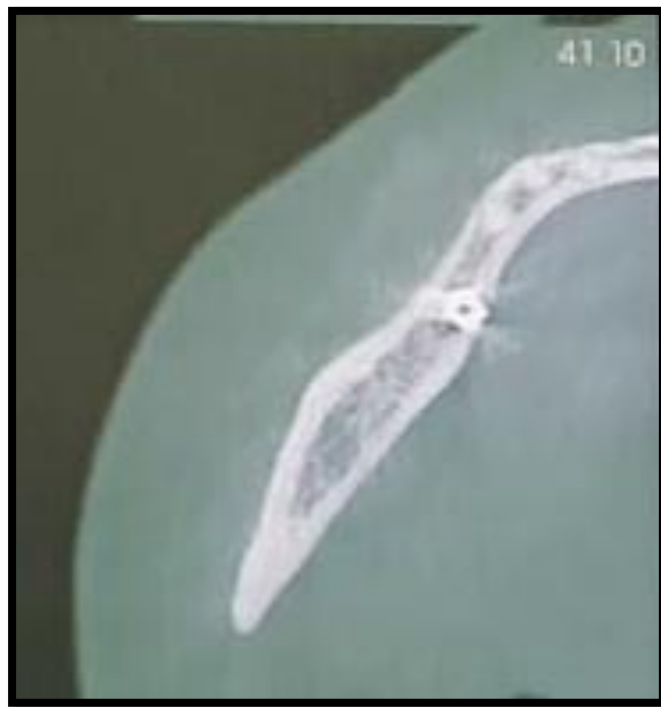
Axial View of CBCT
